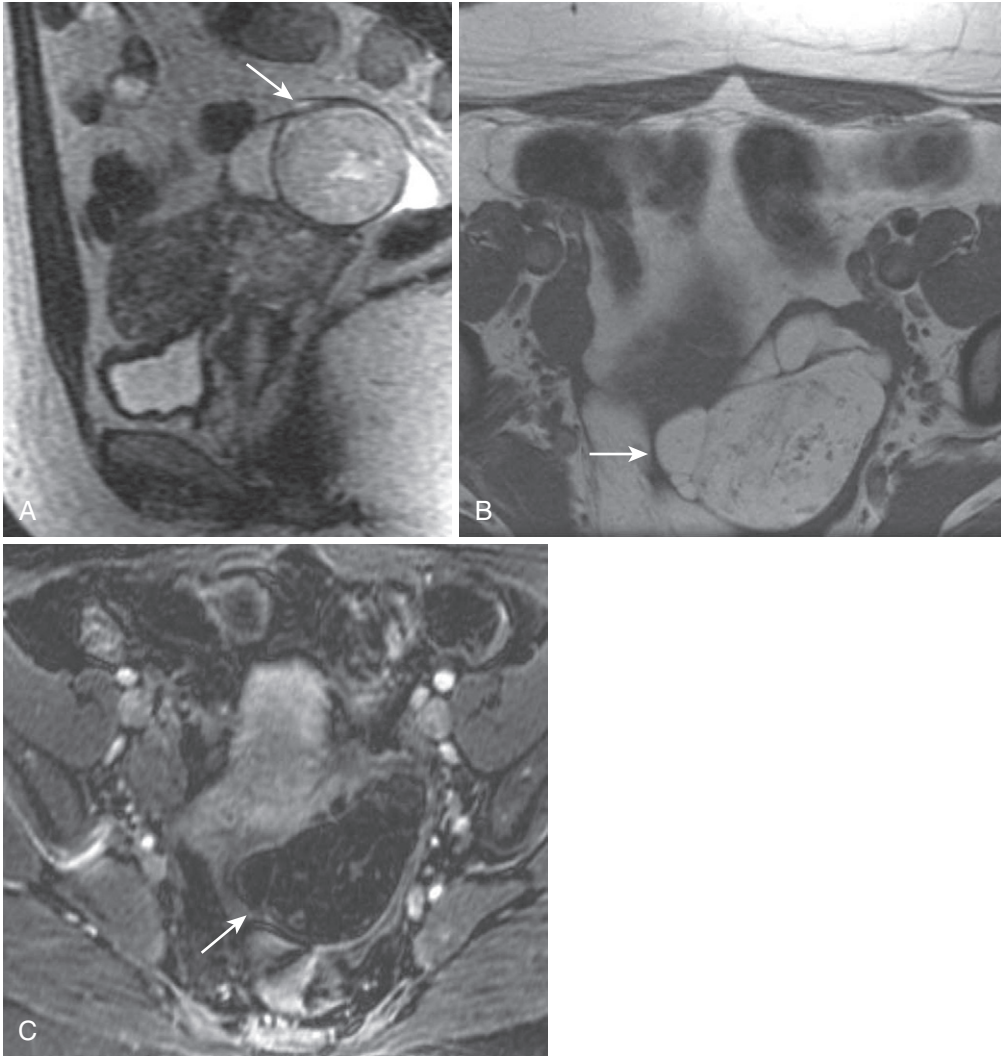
Dermoid cyst. A, The sagittal T2-weighted image reveals a relatively nonspecific moderately hyperintense lesion (*arrow*). B, Axial T1-weighted image reiterates isointensity to fat (*arrow*) and reveals mild complexity—wall thickening and septation. C, The addition of fat saturation (and intravenous gadolinium) confirms predominantly lipid content (*arrow*), an absence of enhancement and the diagnosis of a dermoid cyst.
